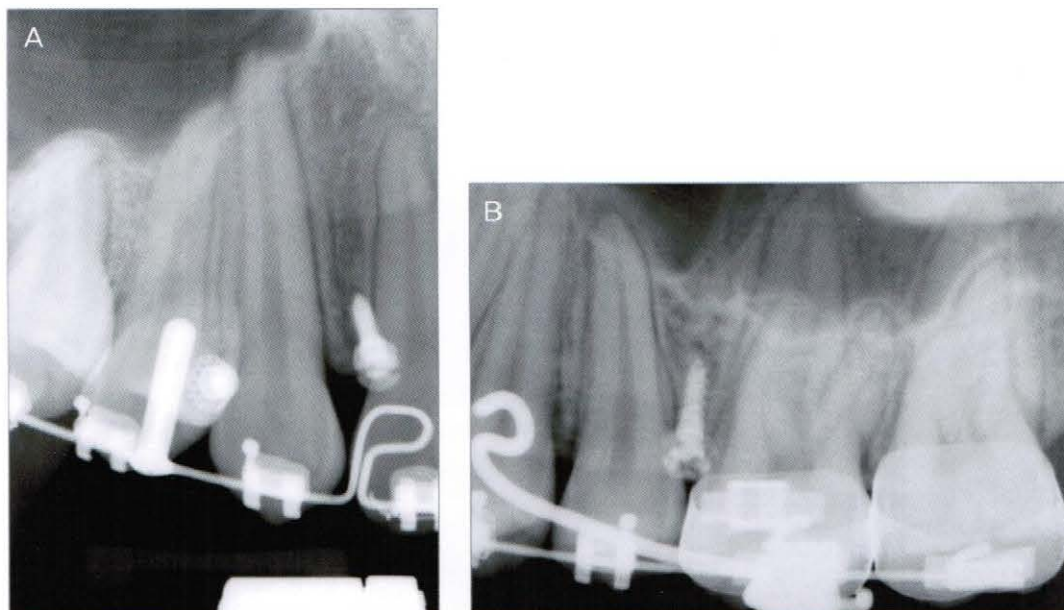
Periapical radiograph to check for root contact between the mini-implant and root (2006, 8,4)
